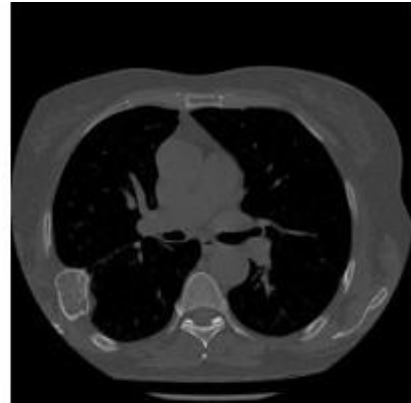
Axial CT scan demonstrating lesion arising from 5th rib (bone window)
